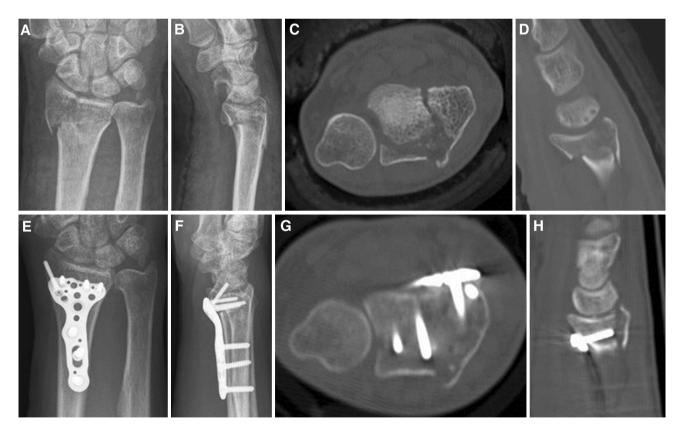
Pre-surgical plain radiographs (A, B) and CT scans (C, D) show the displaced dorsoulnar fragment in the distal radius fracture. The patient was treated with palmar locking plate fixation.
